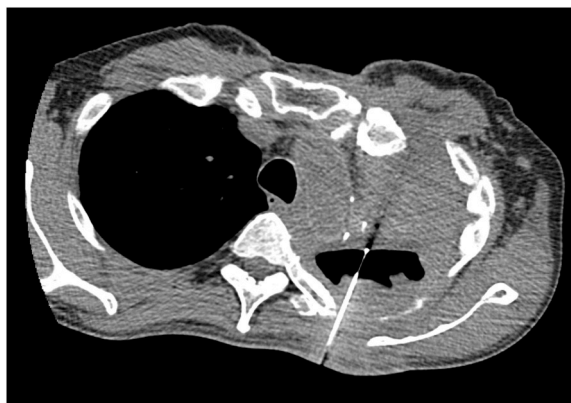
CT view of the abscess during aspiration.
